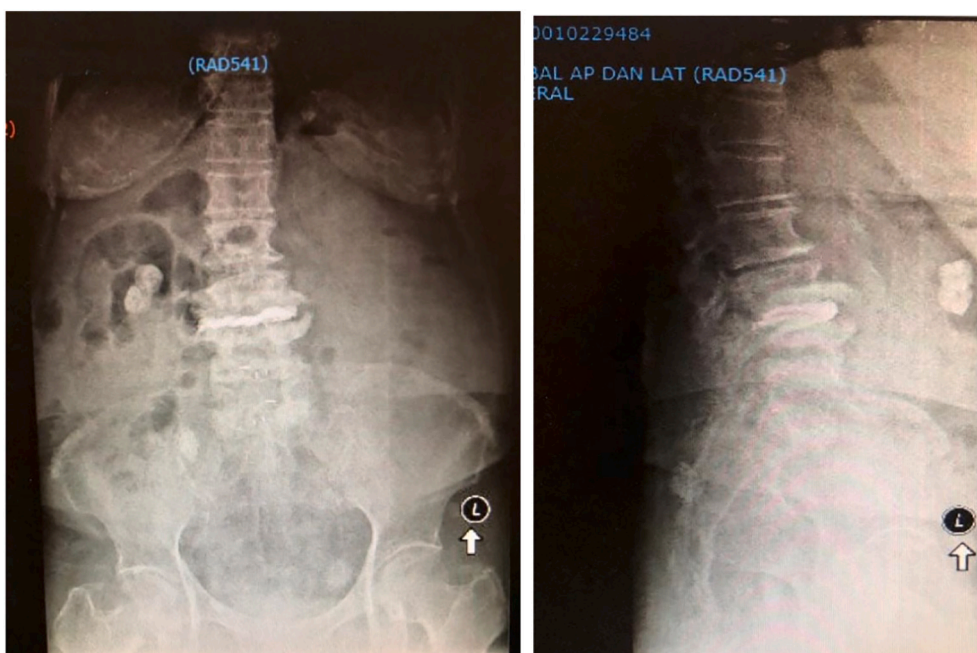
Post-operative X-ray.
